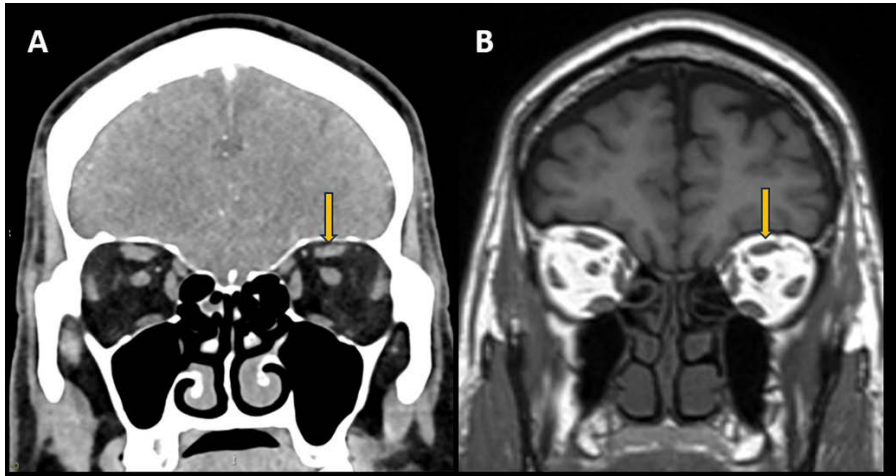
54-year-old male presenting with oculomotor neurovascular conflict. Orbits CT post-contrast (A) and MR T1-weighted pre contrast image (B) on coronal view. Mild atrophy of the left *levator palpebrae superioris*/superior rectus muscles, due to chronic denervation caused by ipsilateral oculomotor nerve compression.
